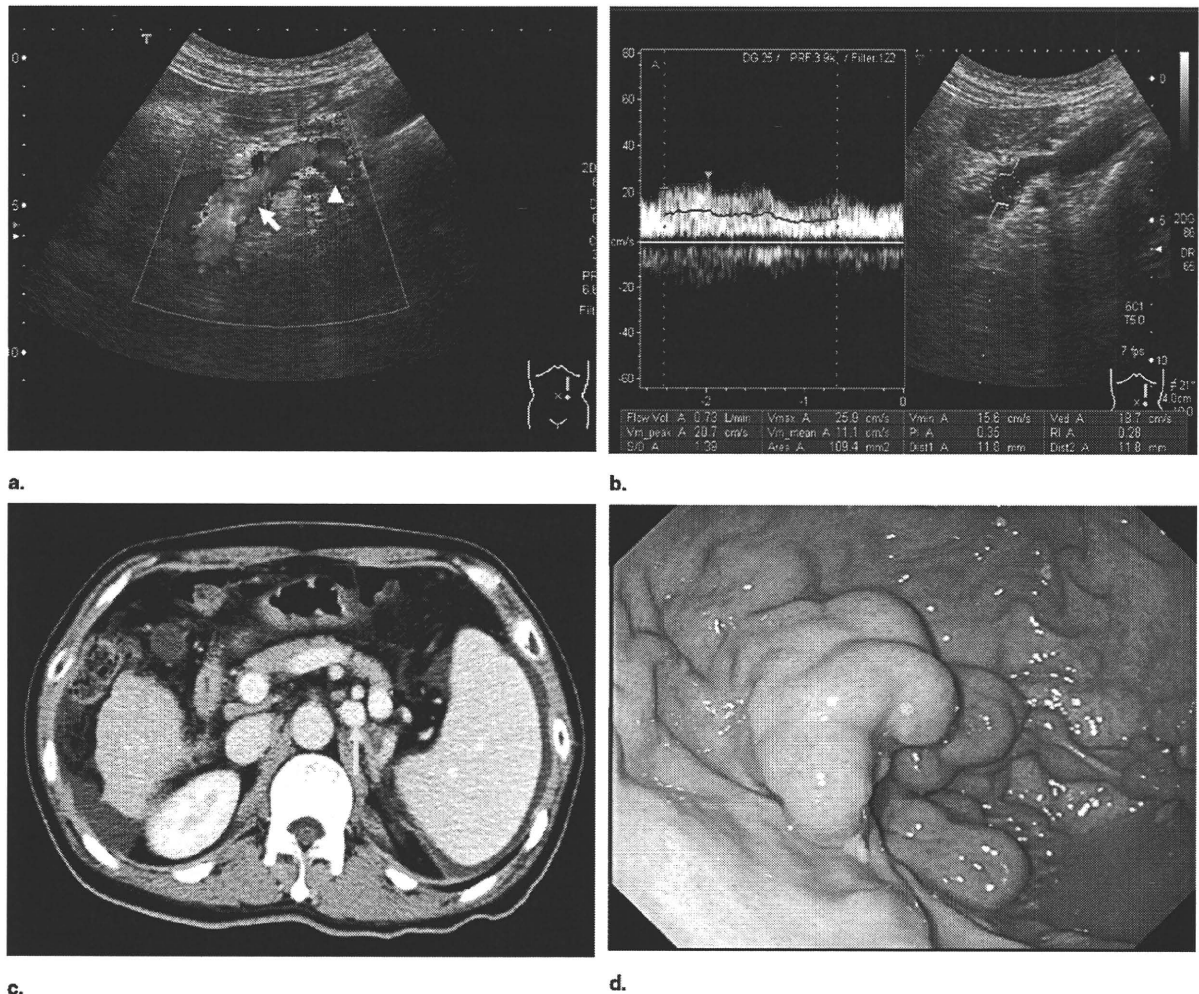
Demonstration of gastroduodenal shunt (GRS) on Doppler ultrasound and contrast-enhanced computed tomography (CECT) images in patient with gastric fundal varices (52-year-old man). (a) The sagittal plane of the color Doppler sonogram demonstrated a long-axis view of GRS (arrow) from the cranial and dorsal side to the caudal and ventral side, which connects into the left renal vein (arrowhead) with a flow direction continuously toward the left renal vein. (b) Pulsed Doppler. Flow velocity and flow volume were measured by the pulsed Doppler method. (c) CECT. CECT demonstrated GRS at the left side of the abdominal aorta (arrow). (d) Endoscopy. This patient had large-grade FV (F3).
